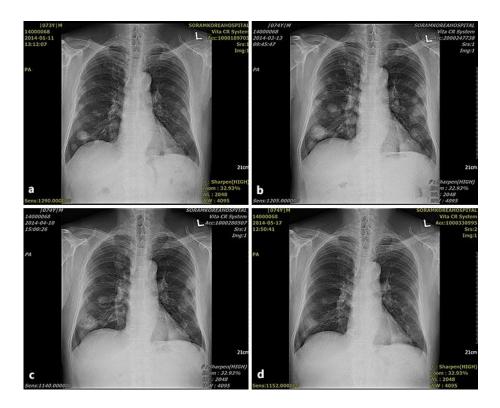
Chest X-ray images. a Image of January 11, 2014. Multiple metastatic nodules were identified in both lungs and KMT was started. b Image of March 13, 2014. Multiple metastatic nodules were increased in number and size after 2 months of treatment with various pharmacopunctures, Soramdan, Gunchildan and CS distillate intake, and Soram nebulizer solution inhalation. c Image of April 10, 2014. A slight improvement was achieved after 1 month of treatment with HND and HAD S intake and Soram nebulizer solution inhalation. d Image of May 17, 2014. A significant improvement was achieved with treatment with HND and HAD S intake and Soram nebulizer solution inhalation for an additional month.
